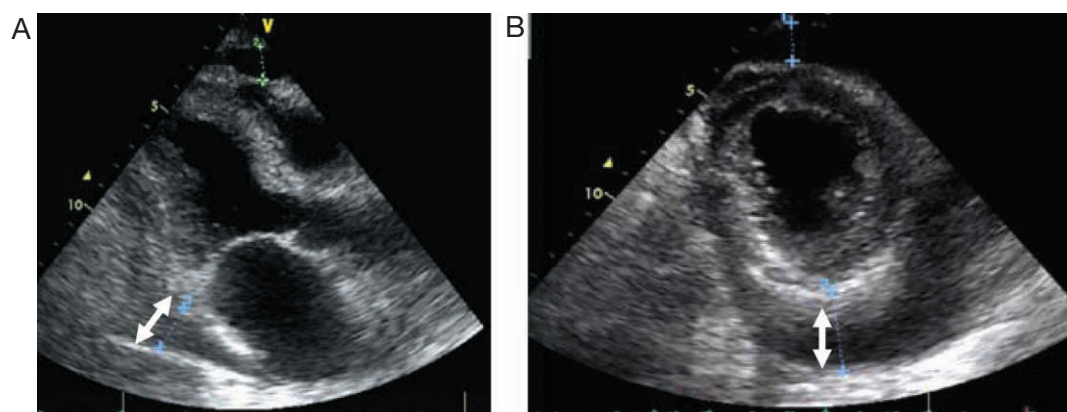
Echocardiography with parasternal long axis (A) and apical views (B) revealing massive amounts of pericardial effusion (arrow) without hemodynamic significance.
